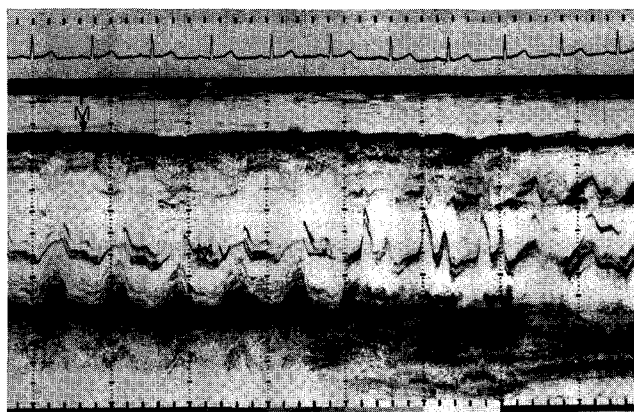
Repeat M-mode echocardiogram two weeks after the initiation of systemic chemotherapy, showing a reduction in the size of the anterior mediastinal mass and disappearance of downward motion of the septum during inspiration. *M* = mass and chest wall, *MV* = mitral valve, and *S* = septum.
